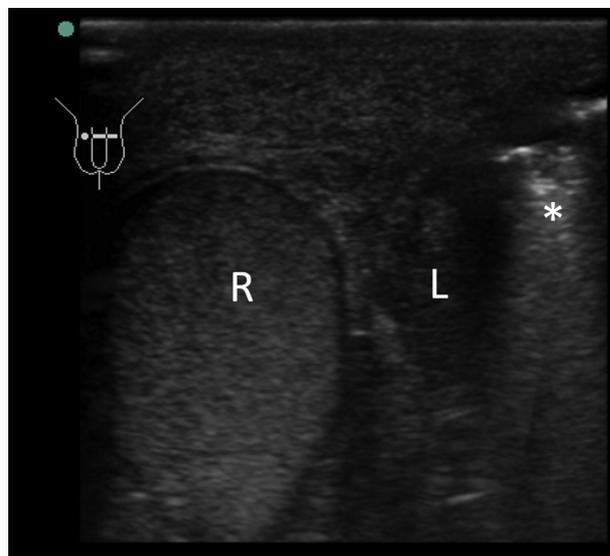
Ultrasonography of the scrotum (transverse orientation), with subcutaneous emphysema (asterisk) masking most of the left testis (L). Note the normal right testis (R).
